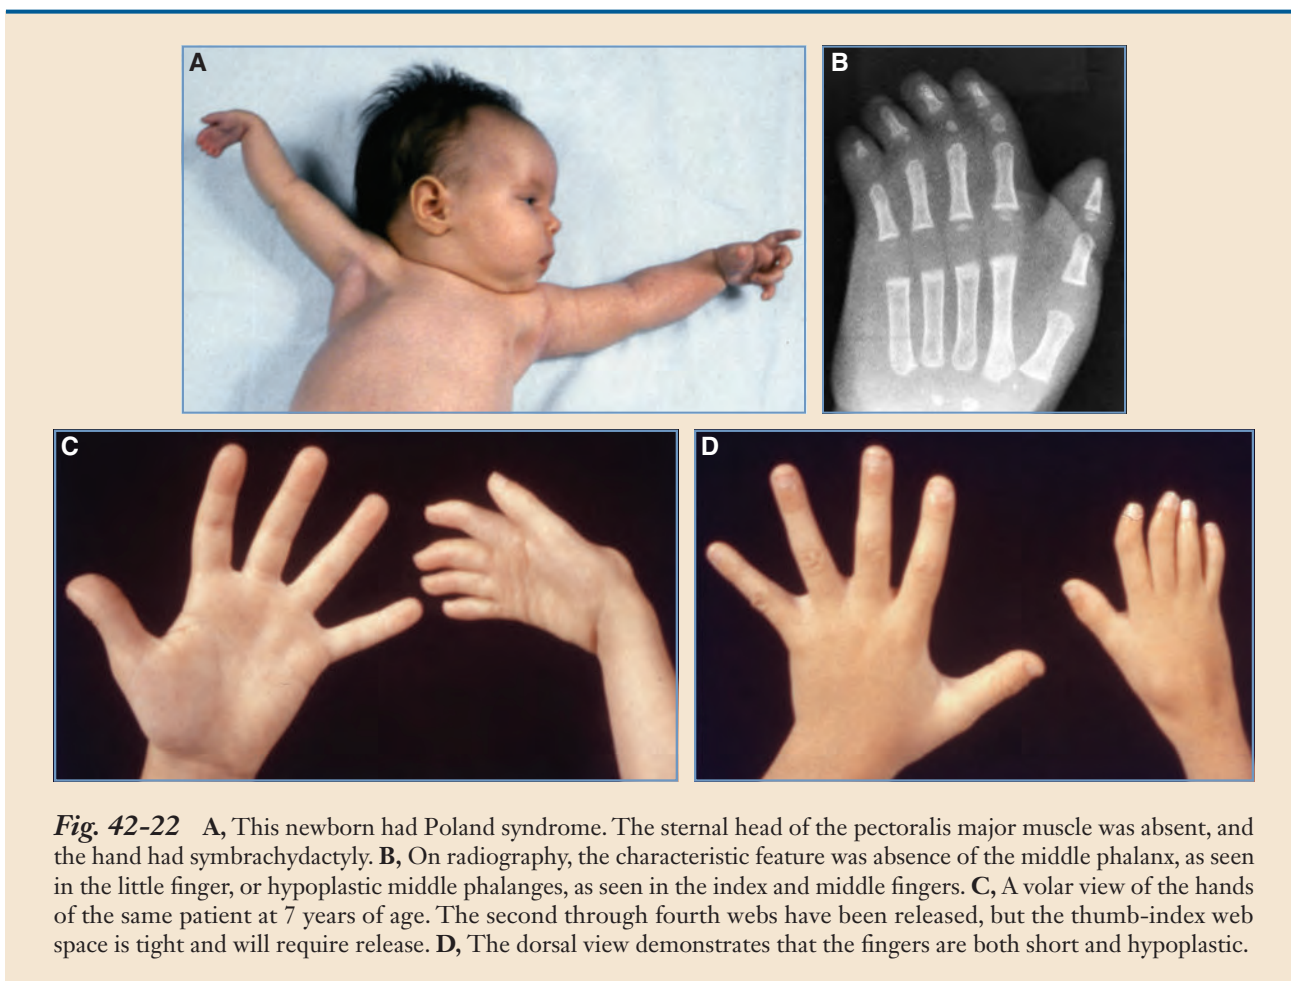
A, This newborn had Poland syndrome. The sternal head of the pectoralis major muscle was absent, and the hand had symbrachydactyly. B, On radiography, the characteristic feature was absence of the middle phalanx, as seen in the little finger, or hypoplastic middle phalanges, as seen in the index and middle fingers. C, A volar view of the hands of the same patient at 7 years of age. The second through fourth webs have been released, but the thumb-index web space is tight and will require release. D, The dorsal view demonstrates that the fingers are both short and hypoplastic.
